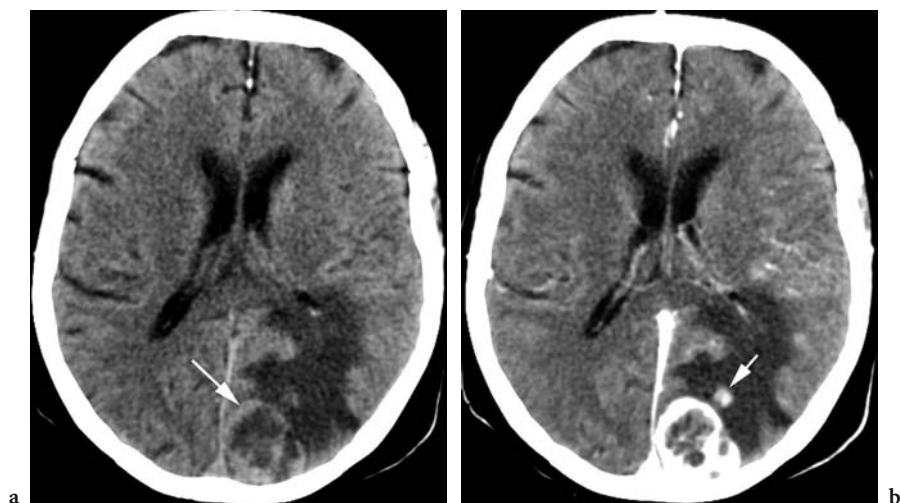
Brain metastases in 72-year-old man who underwent left nephrectomy for renal cell carcinoma. a Axial unenhanced CT scan shows a superficially located parasagittal left occipital heterogeneous large mass with broad base (*arrow*) near the vertex and surrounded by abundant vasogenic edema. b Axial contrast-enhanced CT scan at the same level shows the mass heterogeneously enhancing and also discloses an additional small rounded enhancing lesion (*arrow*) within the same vasogenic edema.
